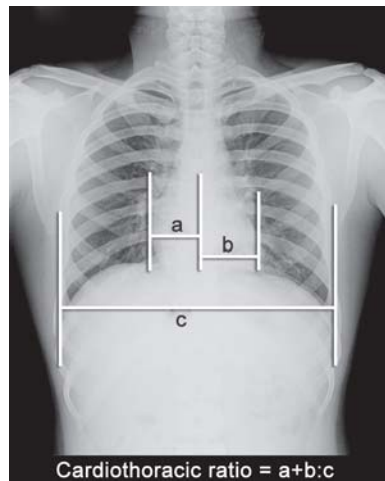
X-ray chest PA view shows measurement of cardiothoracic ratio
